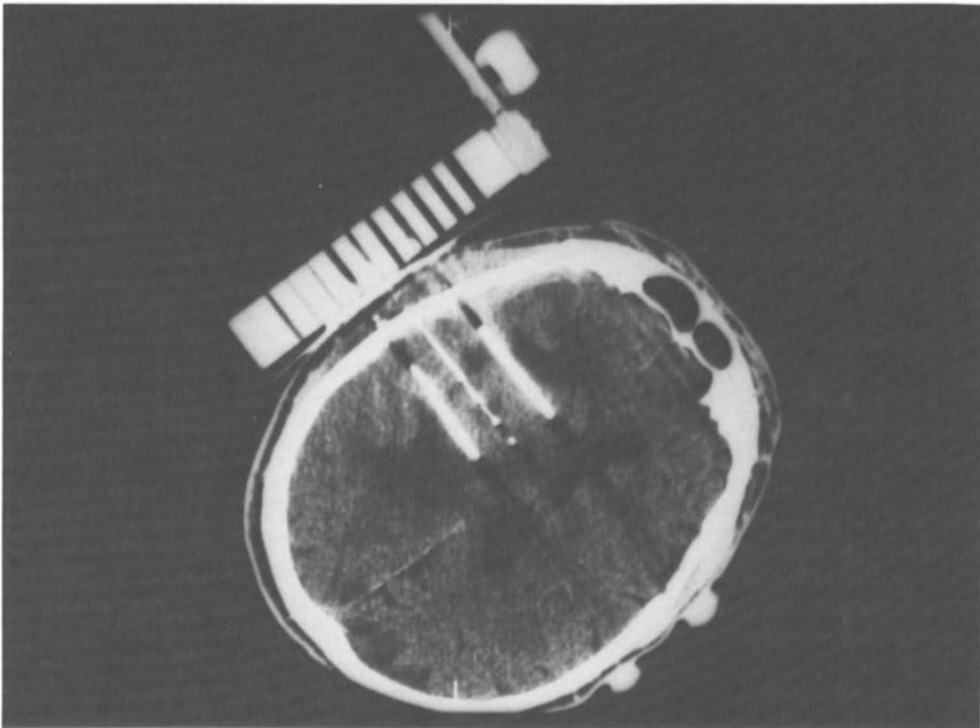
CT scan showing a cross section of the head, with catheters implanted in the tumor through the CT-mounted template. Two hyperthermia catheters and one four-sensor independent thermometry catheter are visible in the image.
